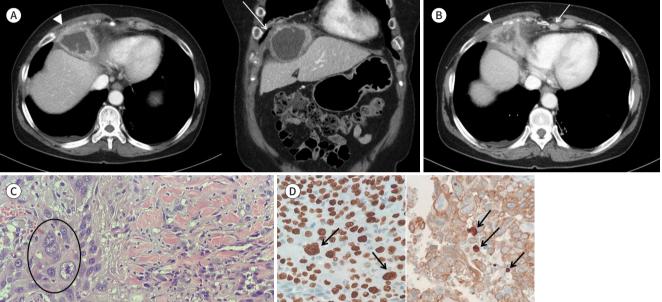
A 68-year-old female with an unusual peritoneal metastasis of late recurrent uterine cervical cancer in the right subphrenic space. A. Axial and coronal images of contrast-enhanced CT show a large necrotic mass (arrowhead) with an irregularly thick enhancing wall and contiguous invasion of the right hemidiaphragm (arrow) in the right subphrenic space.
